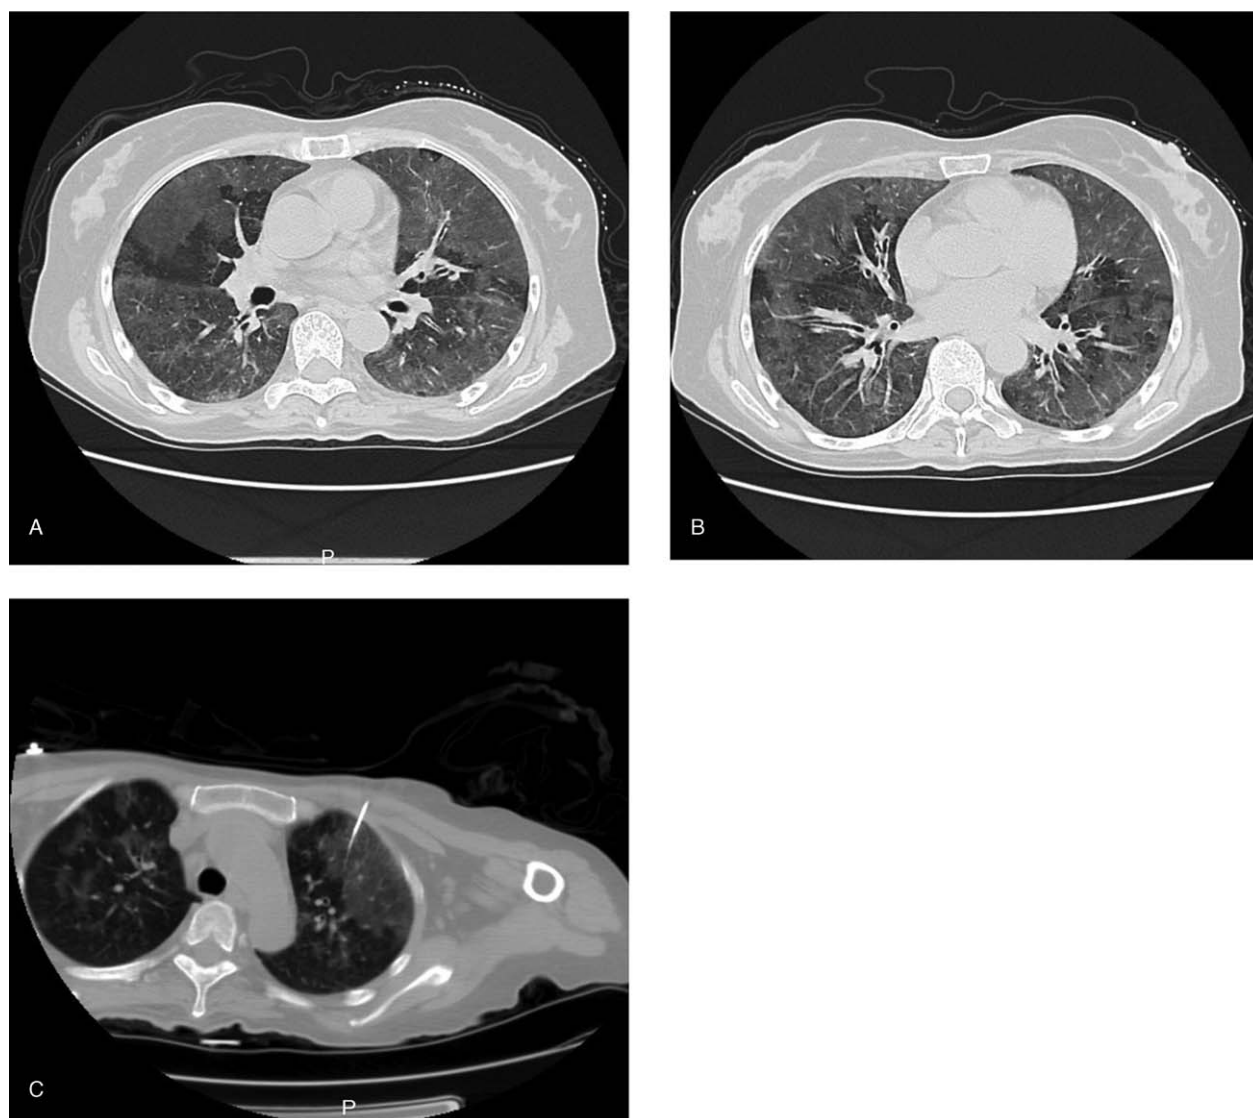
Chest computed tomography of both lungs upon hospitalization. (A and B) Diffuse distribution of homogenous patchy shadows. (C) Multiple calcium deposits in the alveolar cavity and septum.
